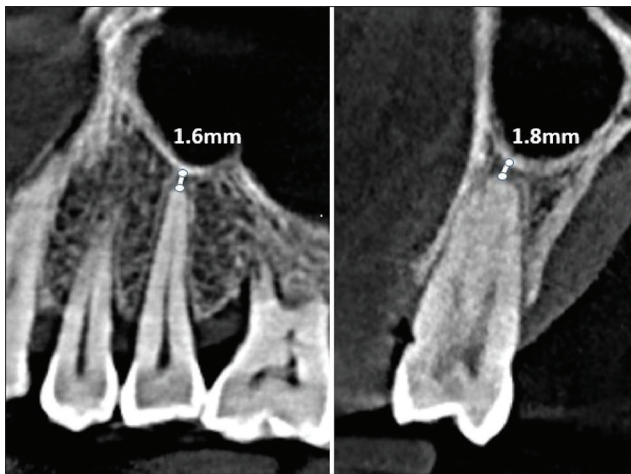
Cone-beam computed tomography images showing measurement of shortest distance between the root apices and adjacent border of maxillary sinus floor in sagittal and coronal planes. The values that were smaller in these two measurements for the same root were recorded
